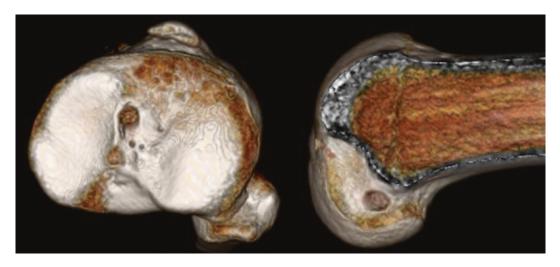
Three-dimensional computed tomography of the knee showing well-positioned tibia and femoral tunnels
